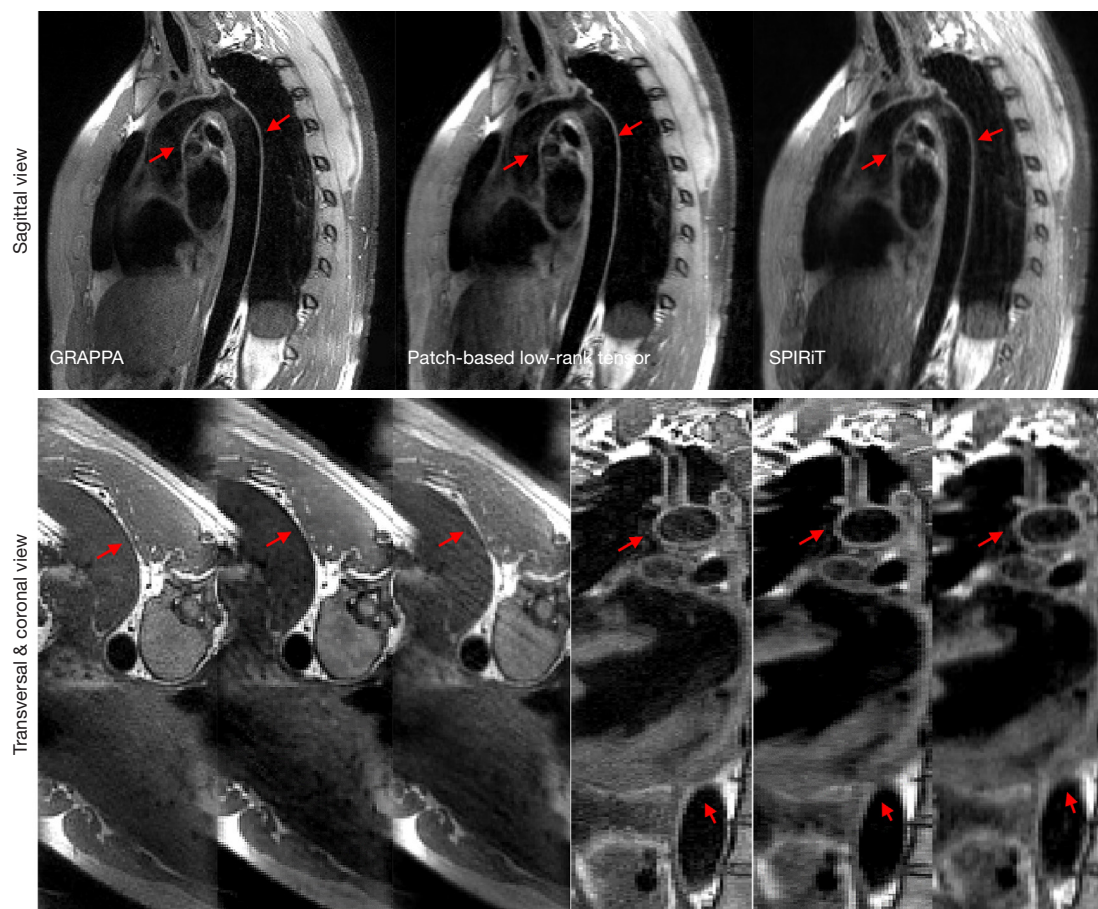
Representative results of the thoracic MRI scans with 3 different views under the GRAPPA, Pt-LRT reconstruction, and ℓ_1 -SPIRiT reconstruction. According to the sharpness quantification in *Table 1*, the vessel definition of Pt-LRT in CNR and sharpness were better than those of the ℓ_1 -SPIRiT reconstruction. The Pt-LRT technique clearly improved overall image quality and produced better vessel sharpness, whereas obvious blurring (the red arrowheads in ℓ_1 -SPIRiT images) was observed in the ℓ_1 -SPIRiT images. There were no significant differences between the Pt-LRT and GRAPPA in the thoracic aorta. The poor blood signal suppression in the aortic arch might have been caused by the incomplete flow void due to slow blood flow in the thoracic aorta (the white arrowheads). MRI, magnetic resonance imaging; GRAPPA, generalized autocalibrating partially parallel acquisitions; Pt-LRT, patch-based low-rank tensor; CNR, contrast-to-noise ratio.
